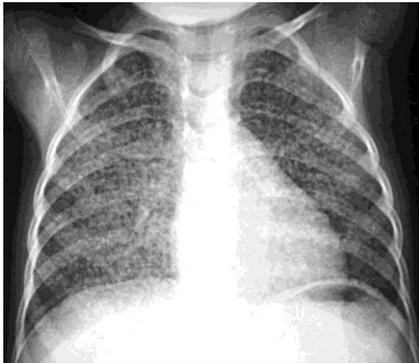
Chest radiograph showing miliary nodules, which are uniform in size and uniformly distributed.
